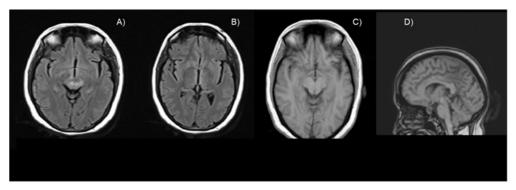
A-B: Plain MRI FLAIR axial images show minimal residual edema in mid brain with normal signal of the thalami, C) Normal plain T1W axial image. D) T1WSE saggital image showing necrosis in prominent size pituitary gland.
